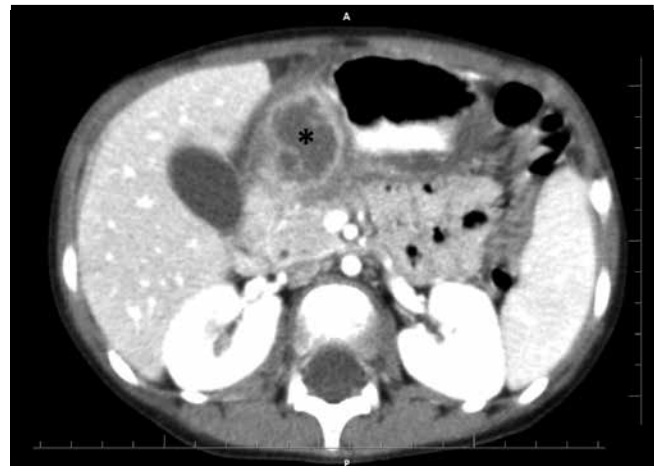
The initial computed tomography image: A cystic lesion (asterisk) measuring 30×28 mm at the gastric antrum
